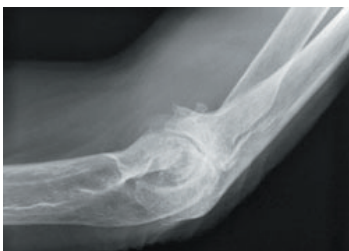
X-ray of elbow showing the humerus, radius, and ulna
